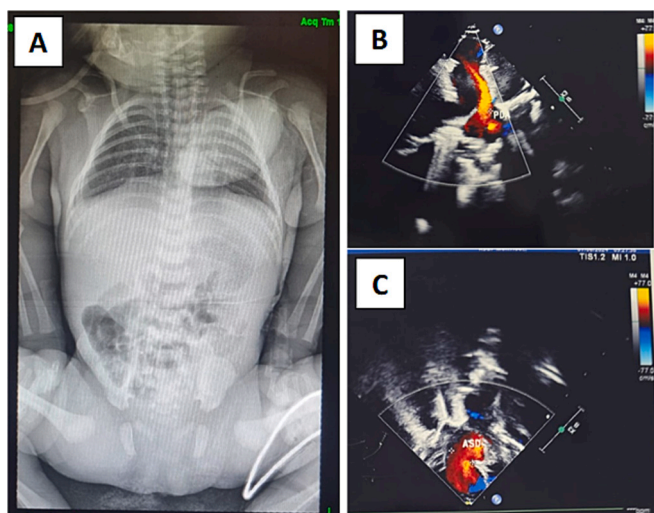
(A) Thoracoabdominal x-ray resulted heart is located outside the thoracic cavity, (B) echocardiography resulted balance four chambers with result patent ductus arteriosus, (C) atrial septal defect measuring 7-8 mm.
